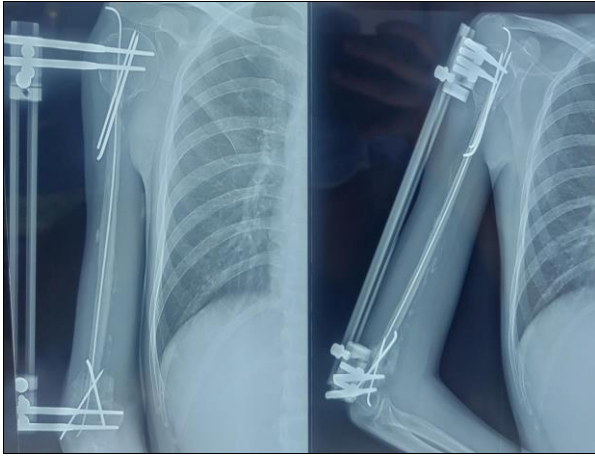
Six months post-operative x-ray showing sign of better osteo integration and healing.
